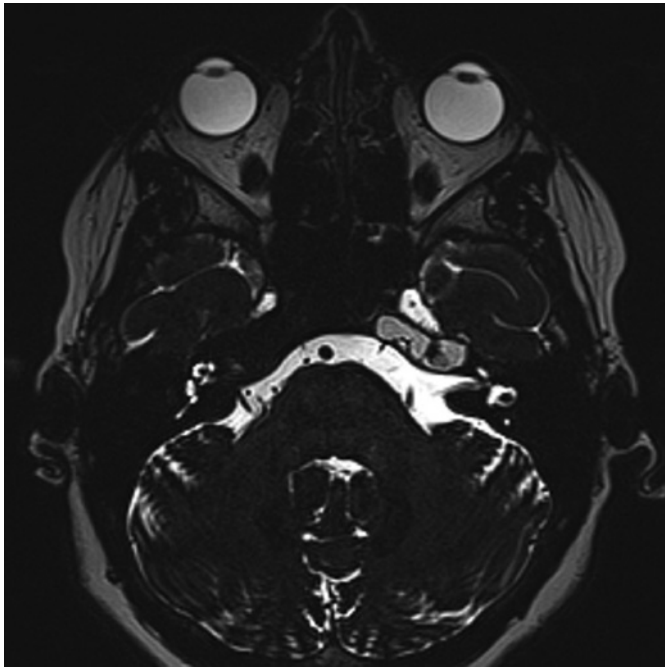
Axial T2-weighted MRI scan showing cholesterol granuloma compressing the left abducens nerve at its exit from the brainstem.
